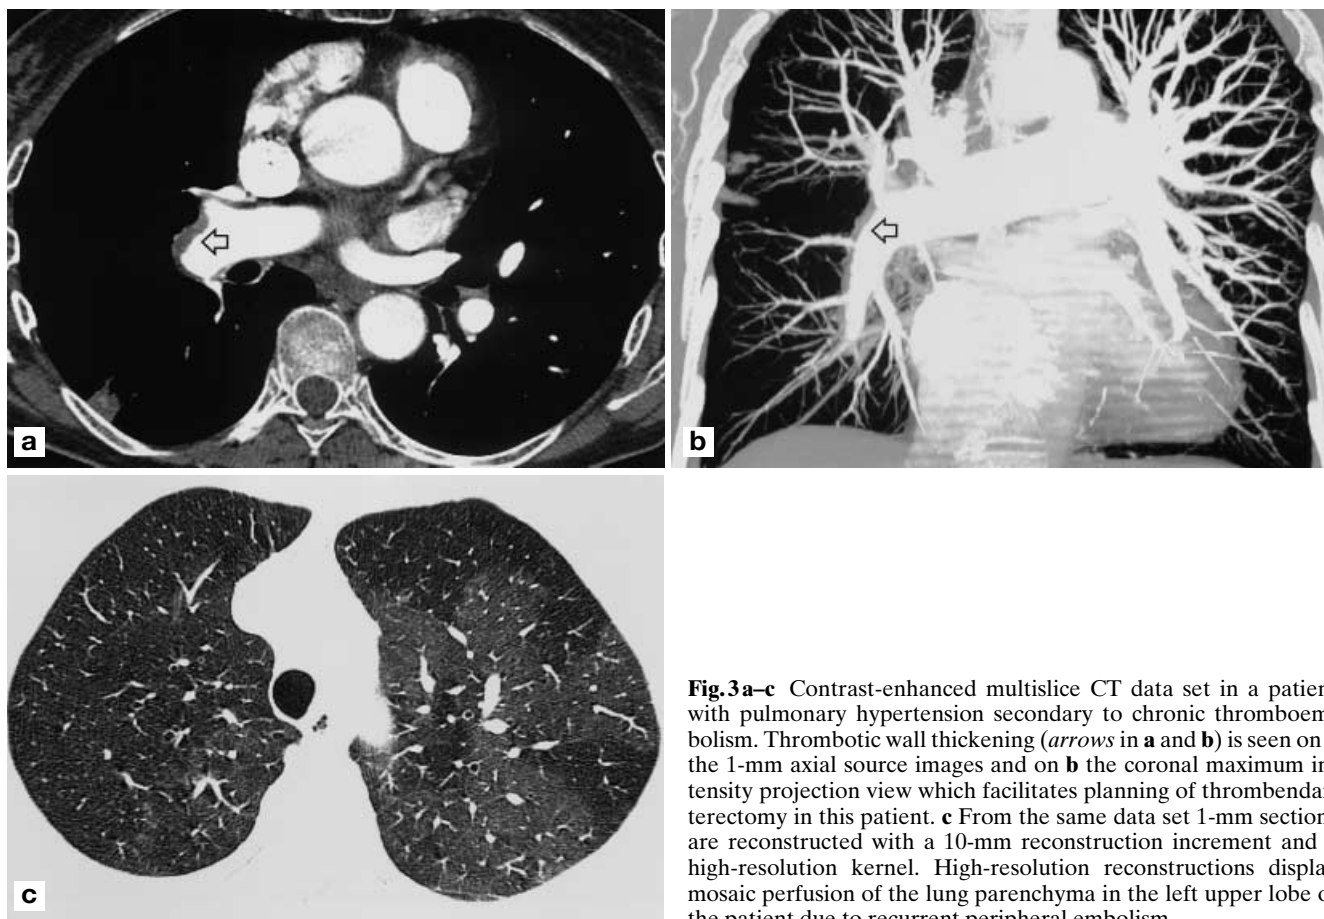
a–c Contrast-enhanced multislice CT data set in a patient with pulmonary hypertension secondary to chronic thromboembolism. Thrombotic wall thickening (*arrows in a and b*) is seen on a the 1-mm axial source images and on b the coronal maximum intensity projection view which facilitates planning of thrombendarterectomy in this patient. c From the same data set 1-mm sections are reconstructed with a 10-mm reconstruction increment and a high-resolution kernel. High-resolution reconstructions display mosaic perfusion of the lung parenchyma in the left upper lobe of the patient due to recurrent peripheral embolism
